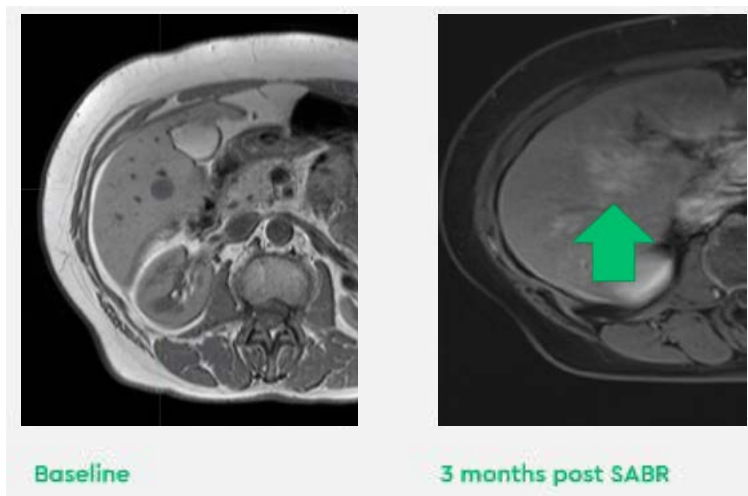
Post-treatment MRI scan, showing a well demarcated ablation zone
